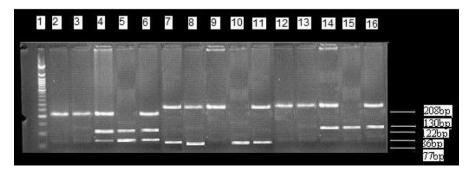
Vegf +936C/T polymorphism Lane 1–50 bp ladder, Lane 2,3-TT genotype, Lane 4 & 6-CT genotype, Lane 5-CC genotype; VEGF –2578C/A polymorphism Lane 7,8-CA genotype, Lane 9,10-AA genotype, Lane 11,12-CC genotype; VEGF -1154G/A polymorphism Lane 13,14-AA genotype, Lane 15,16-GA genotype.
